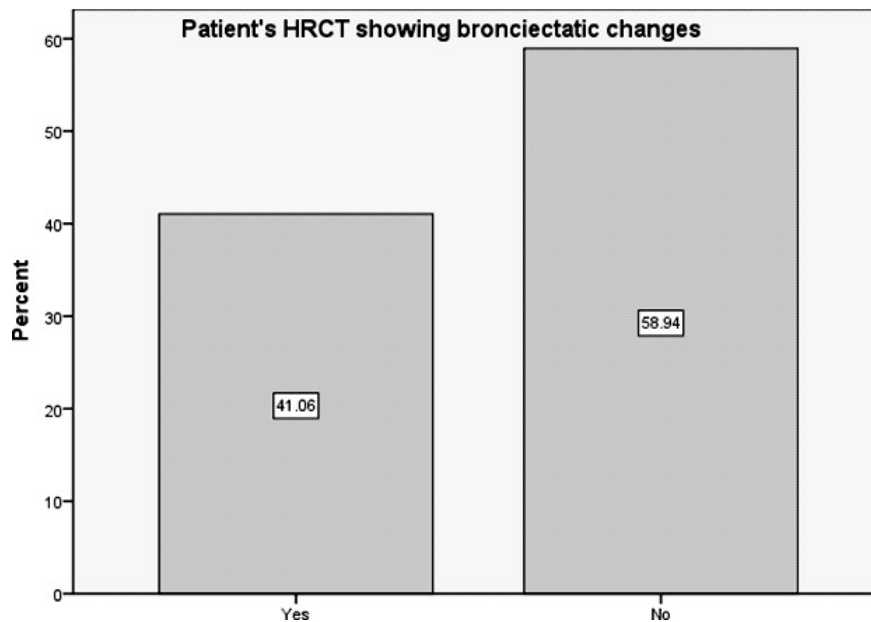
Prevalance of Bronchiectatic changes on HRCT (n=151)
